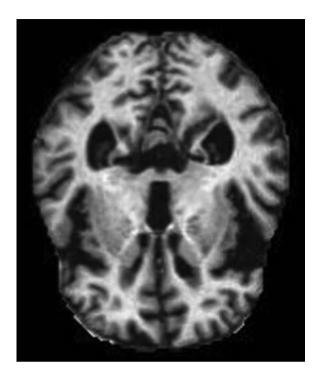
MRI of a mildly demented patient.
